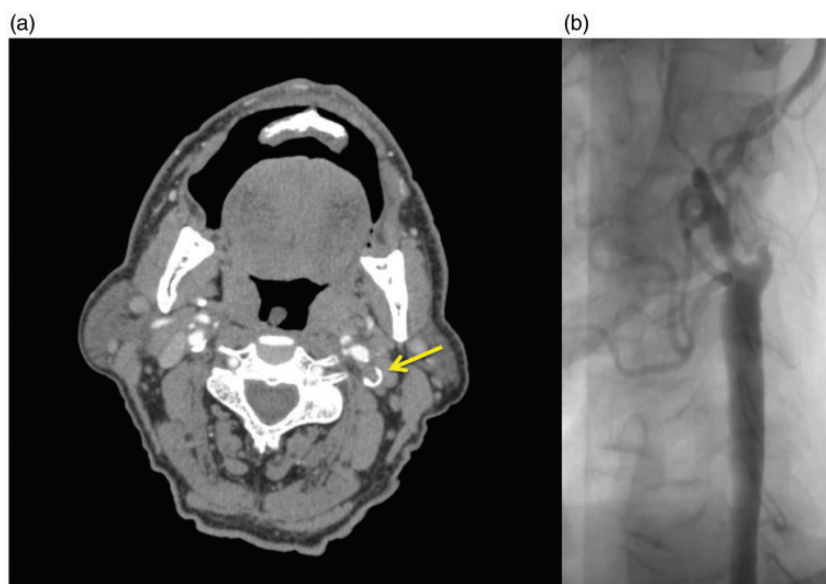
CT angiography of supra-aortic vessels showing the occlusion of the left internal carotid artery (a, arrow). Carotid angiogram showing the occlusion at the origin of the left internal carotid artery (b).
